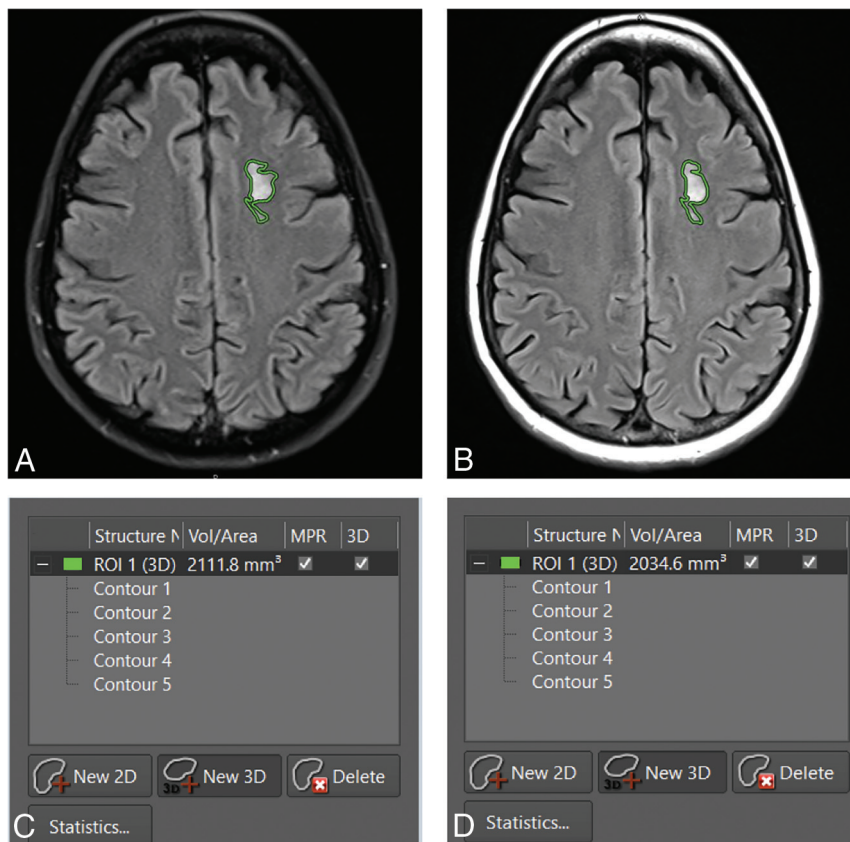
Representative FLAIR images from the baseline (A) and the second (B) MR imaging of a patient with a left-frontal MVNT (segmented in green). C and D, Images corresponding to the MR imaging examinations shown in A and B, respectively, show what the segmentation volume window looks like in our PACS.
